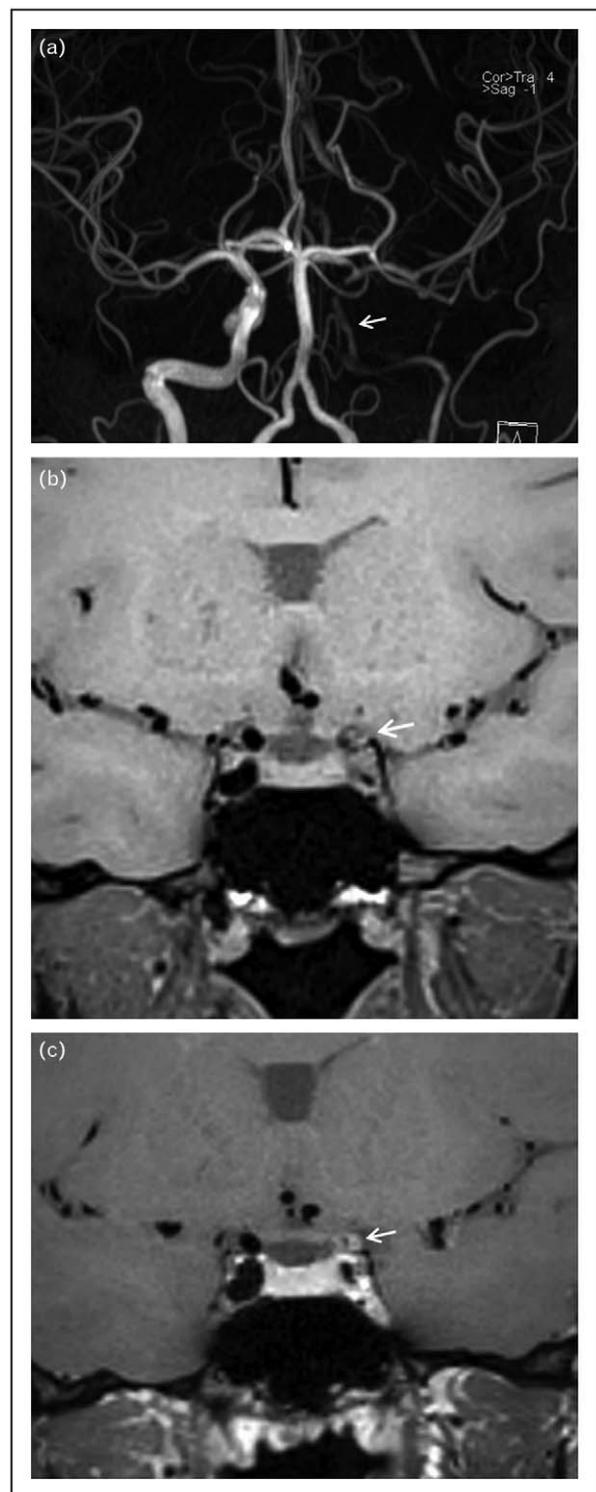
Central nervous system vasculitis. (a) A 33-year-old female patient presented with features suggestive of a transient ischemic attack. Time-of-flight magnetic resonance angiography shows a low-caliber flow in the left internal carotid artery. Vessel wall MRI performed (b) pre and (c) postgadolinium images show luminal narrowing and concentric enhancement in the left internal carotid artery supraclinoid segment.
